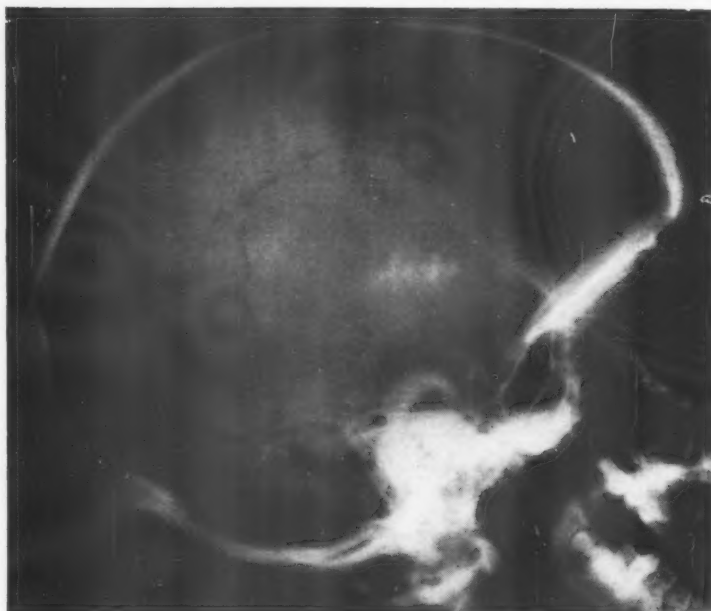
Lateral radiograph of skull of J.P. showing less extensive calcification.
